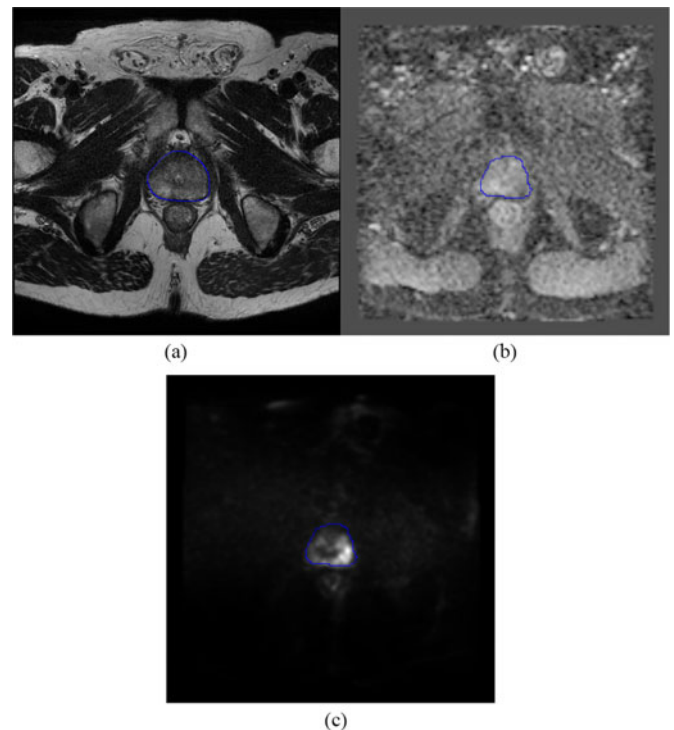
Sample mpMRI slices of the same prostate gland, using T2w and DWI. The lower-right corner of the prostate gland, outlined in blue, which appears dark on ADC and bright on CDI, was indicated as tumorous by an expert. (a) T2-weighted. (b) DWI: ADC. (c) DWI: CDI.
